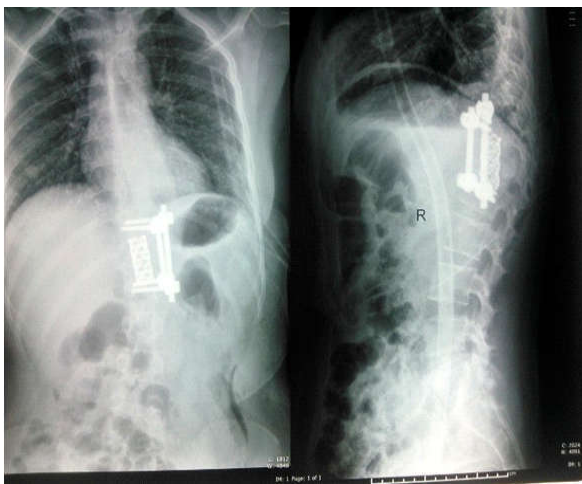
Showing postoperative X-ray instrumentation with cage, screws and rods
